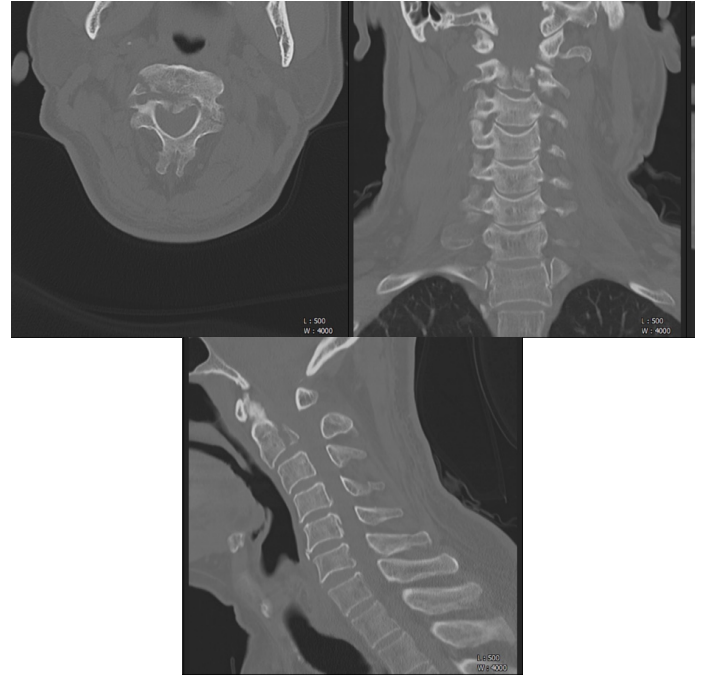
CT shows Hangman's fracture of C2 extends through the C2 body and both pedicles with spondylolisthesis of C2 on C3.
